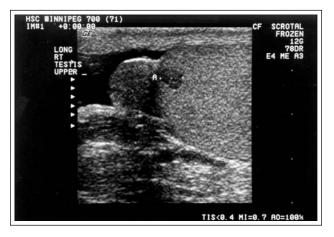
Ultrasound image of a 6 mm mass in the upper pole of the right testis.
